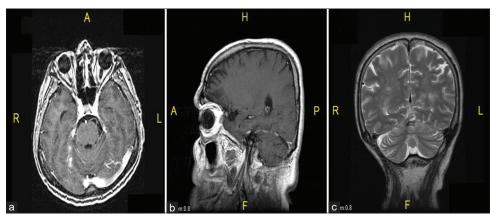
(a-c) Postoperative magnetic resonance images demonstrating no residual tumor. (a) Axial enhanced T1 imaging. (b) Sagittal enhanced T1 imaging. (c) Coronal T2 imaging
